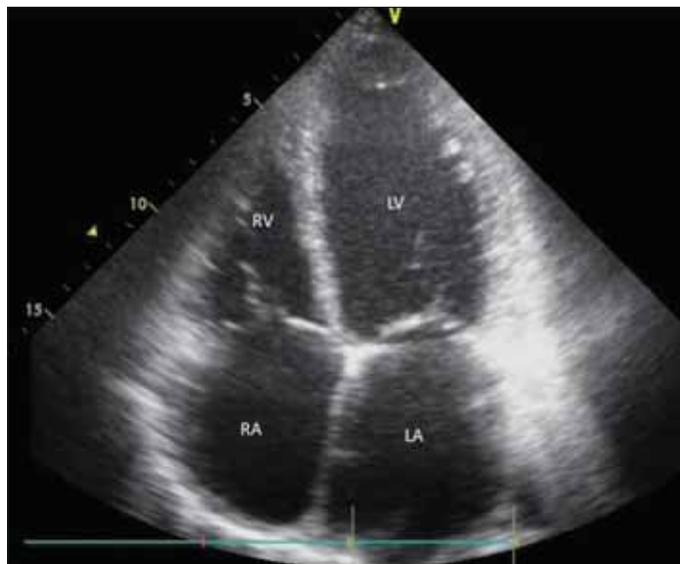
Transthoracic echocardiographic image in apical four-chamber view: Twenty-four hours after streptokinase treatment no signs of thrombi are seen
